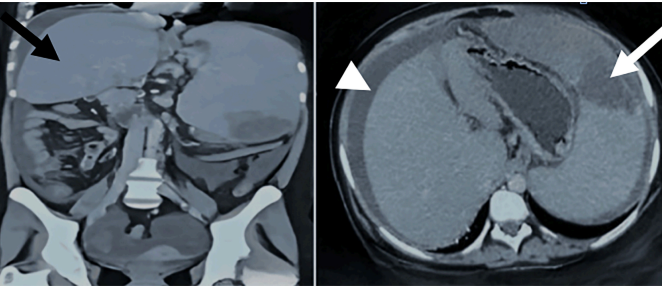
Contrast-enhanced CT of abdomen. Left-coronal section - healthy liver tissue (black arrow). Right-transverse section-wedged shaped area of infarction in the spleen (white arrow) and ascites (white arrow head).
